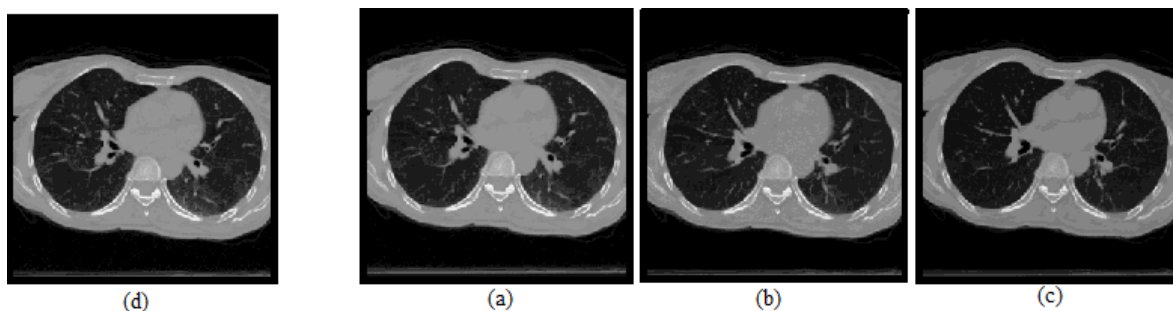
Image reconstruction between two frames of CT image sequences consists of two steps:
